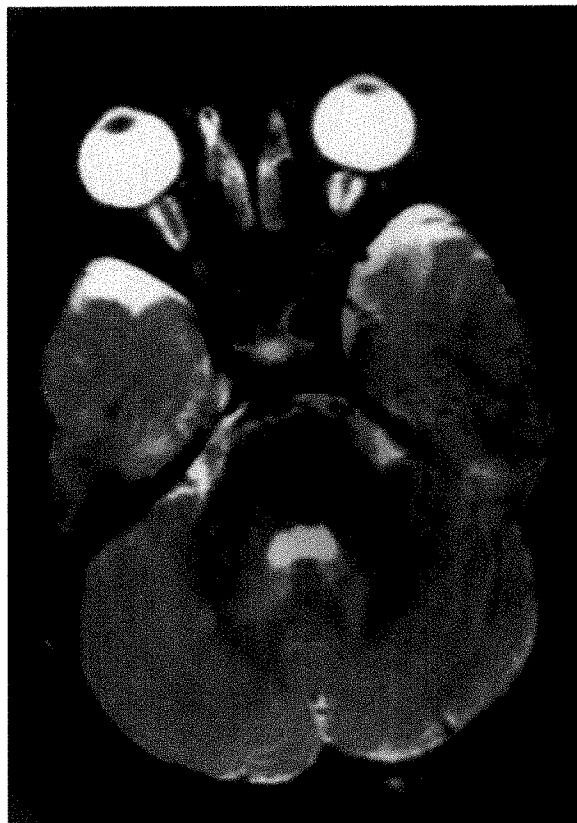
(Imes and Hoyt). Case 3. T₂-weighted axial magnetic resonance image. The optic nerves are tubularly thickened and kinked. Anteriorly in each nerve, a rim of high signal intensity surrounds a core of low signal intensity.
